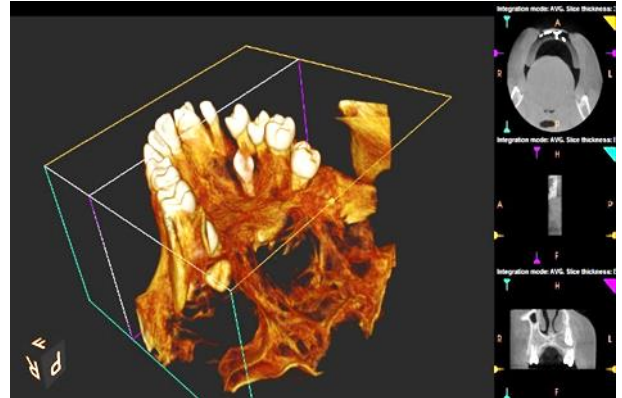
Preoperative images from CBCT.
